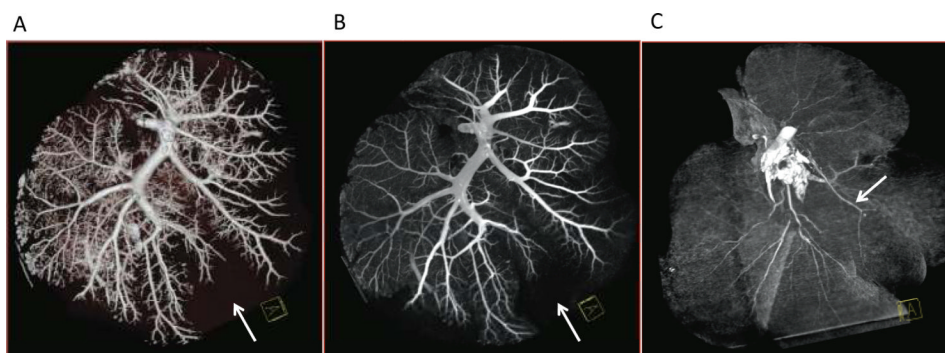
Maximum intensity projection (MIP) images of hepatic vasculature from CT angiogram (CTA) protocol
